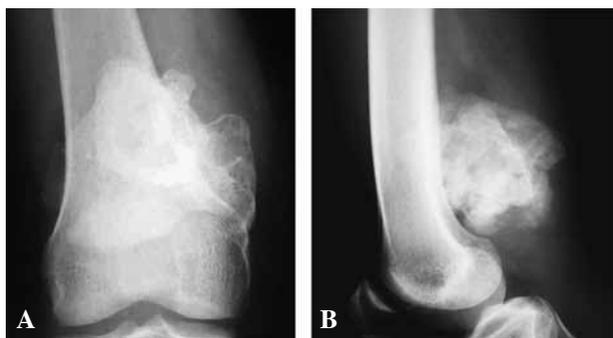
Radiographs taken after the tumour recurred following the initial resection, showing a well-delineated completely ossified mass located at the posterior aspect of the distal femur, which appeared to be in close contact with the bone.
